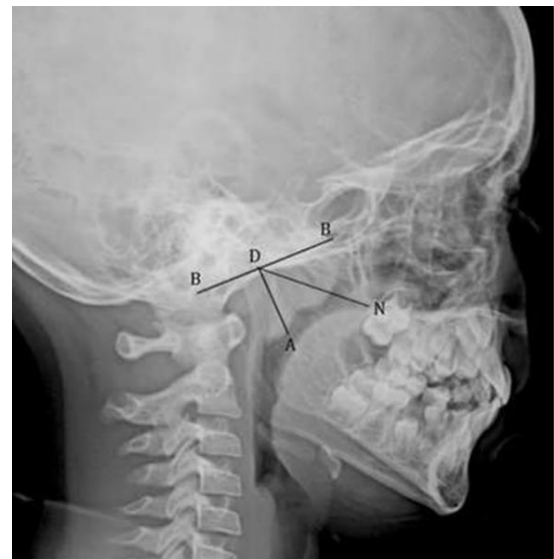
Cephalometric radiograph, where BB is the line drawn along the straight part of the anterior margin of the basiocciput; AD is the adenoid depth; ND is the nasopharyngeal depth (17).
